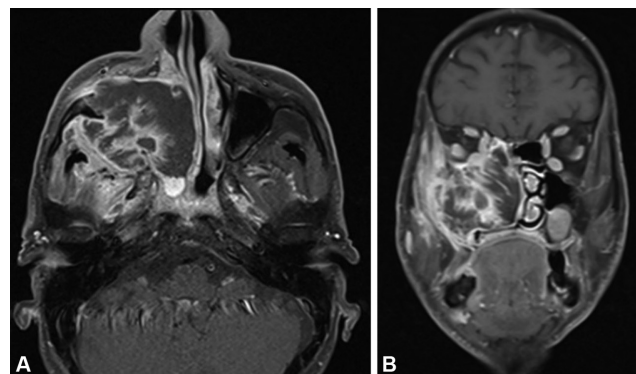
Well-differentiated squamous cell carcinoma of maxillary sinus. (A) Axial post-gadolinium T1-weighted image with fat suppression shows heterogeneously enhancing irregular mass in the right maxillary sinus with destruction of its anterior and posterior walls and invasion of the subcutaneous tissue and pterygoid fossa, respectively. (B) Coronal post-gadolinium T1-weighted image with fat suppression shows the mass invading into the orbital fat and ethmoid sinus.
